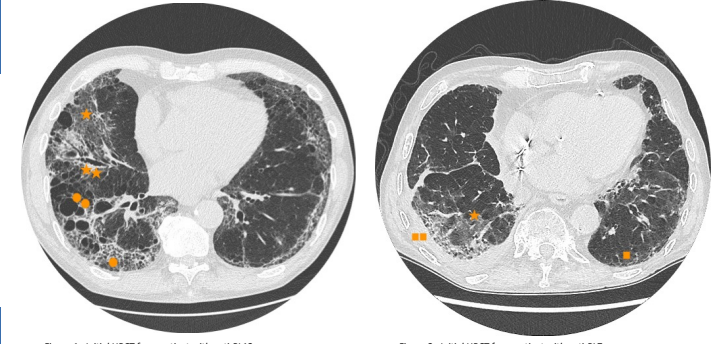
Initial HRCT from patient with anti-PL12
